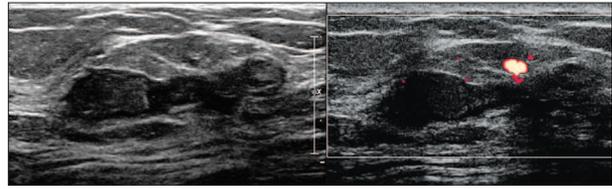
Images from a 44-year-old woman with a history of right mastectomy who underwent sonography for a palpable lesion in her left breast. Left and Right, Sonograms showing an elongated cystic and solid hypoechoic mass in her left breast. Considering her cancer history, this lesion was assessed as BI-RADS category 4B (intermediate concern for malignancy). A sonographically guided 14-gauge core needle biopsy was performed, and pathologic findings confirmed chronic inflammation.
